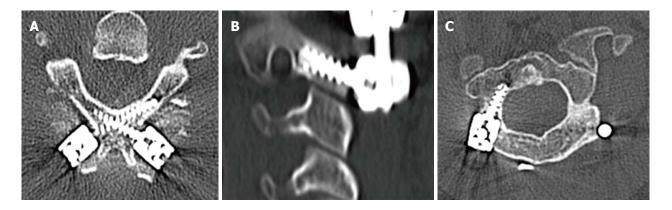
C2 screw fixation. A: Axial cut computed tomography (CT) scan of intralaminar screw placement at C2. The starting point on the spinous process can be seen as well as the space available for screws; B: Sagittal cut CT of a patient who underwent instrumentation with C2 pars screws. Note the relationship of the vertebral artery in this patient and the need for shorter screw placement; C: Axial CT demonstrating the medial orientation of a C2 pedicle screw with the spinal canal medial and the vertebral artery anterior and lateral.
